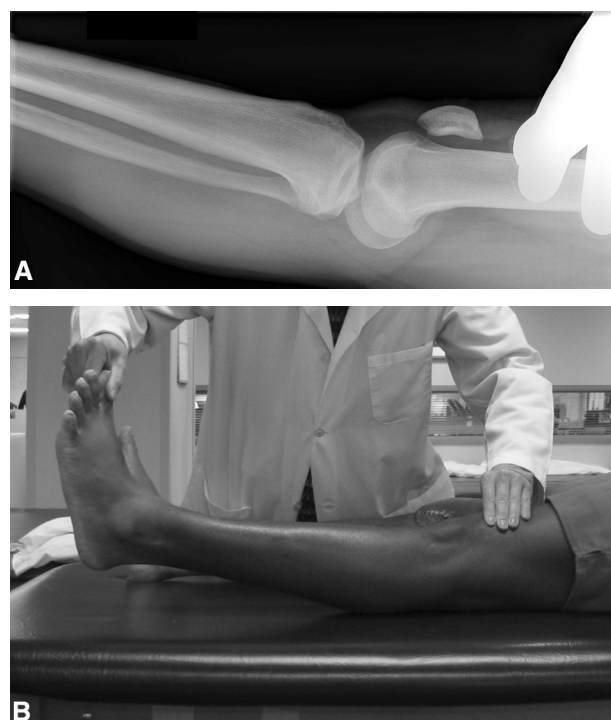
Radiograph (A) and clinical examination (B) of a patient with a positive external rotation recurvatum test finding.
